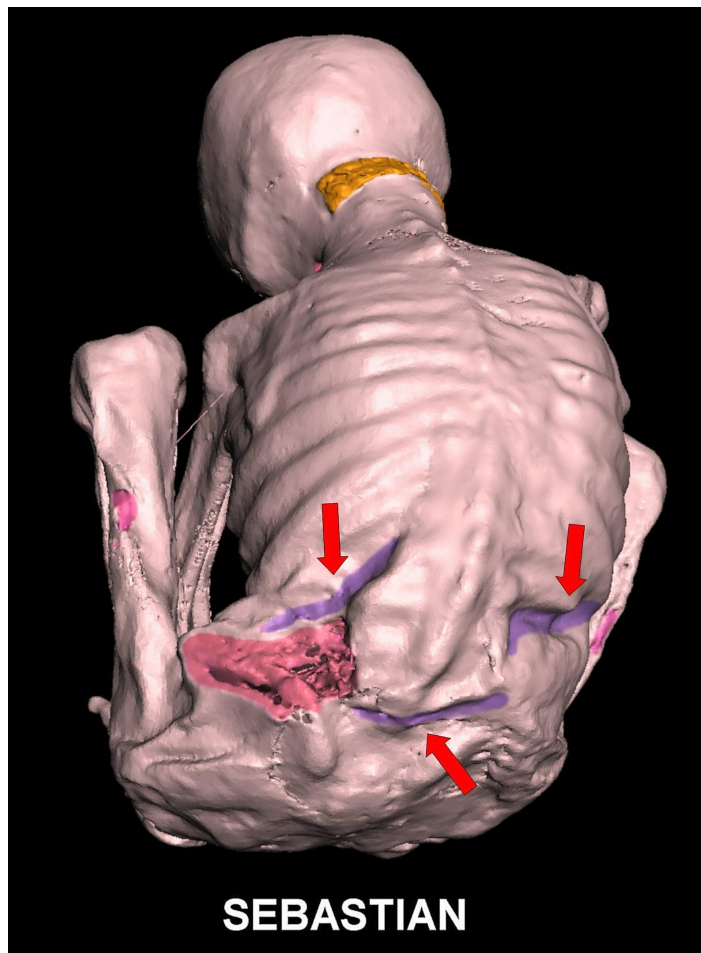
3D CT showing presence of deep band shaped (*in purple*) impressions (*red arrows*) on skin surface of bilateral loins and above sacral area.
